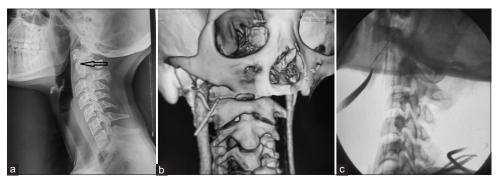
(a) Plain radiograph neck lateral view showing radiopaque linear shadow at C1-C2 vertebra level (black arrow), (b) Contrast-enhanced CT scan neck (3D reconstruction) showing close proximity of vital structures to the radiopaque linear foreign body, (c) C-arm X-ray confirms the site of foreign body intraoperatively
